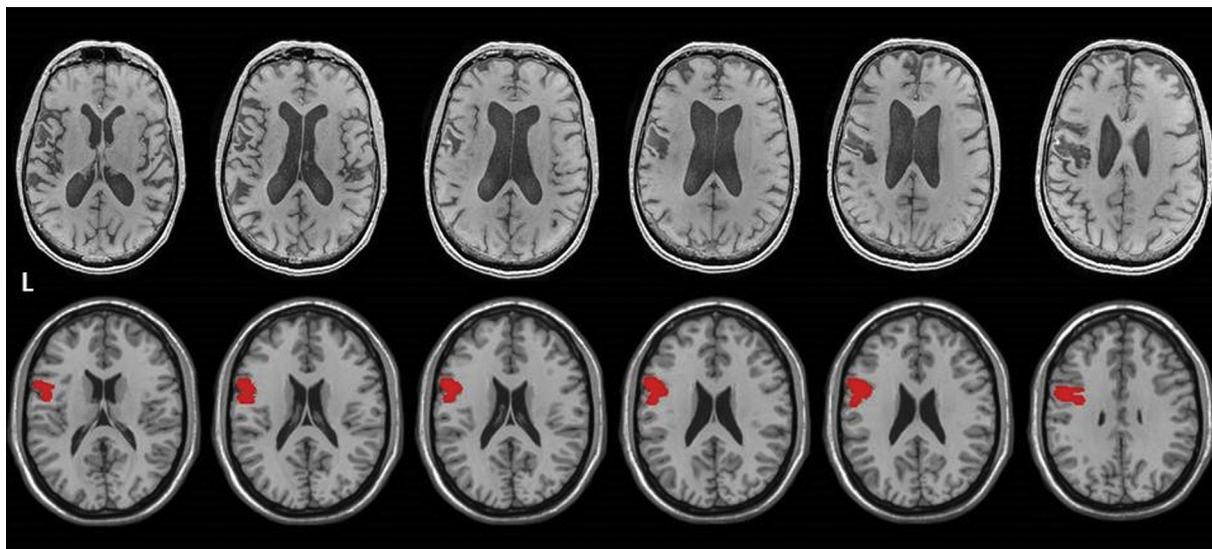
The upper row shows patient's T1-weighted magnetic resonance imaging (1 mm-thick slices acquired on a 3T MRI). Images have been mirrored. The second line shows the reconstruction of the brain MRI scans on MRlcro version 1.4 (MRlcro program). Slices at the approximate levels of the original MRI scans are represented. The ischemic areas are marked in red. Cortical lesions can be seen on the pre-central gyrus (about 47% of the volume of the entire ischemic lesion), the inferior frontal gyrus (Broca's area, about 20%), the Rolandic operculum (about 10%), the post-central gyrus (about 7%). Of note, less than 1% of the damage affects the temporal lobe (superior temporal gyrus - Wernicke's area). The ipsilateral subcortical nuclei and the insula are spared. Subcortical lesions can be seen within the cerebral white matter (about 15% of the total lesion volume). (For interpretation of the references to colour in this figure legend, the reader is referred to the Web version of this article.)
